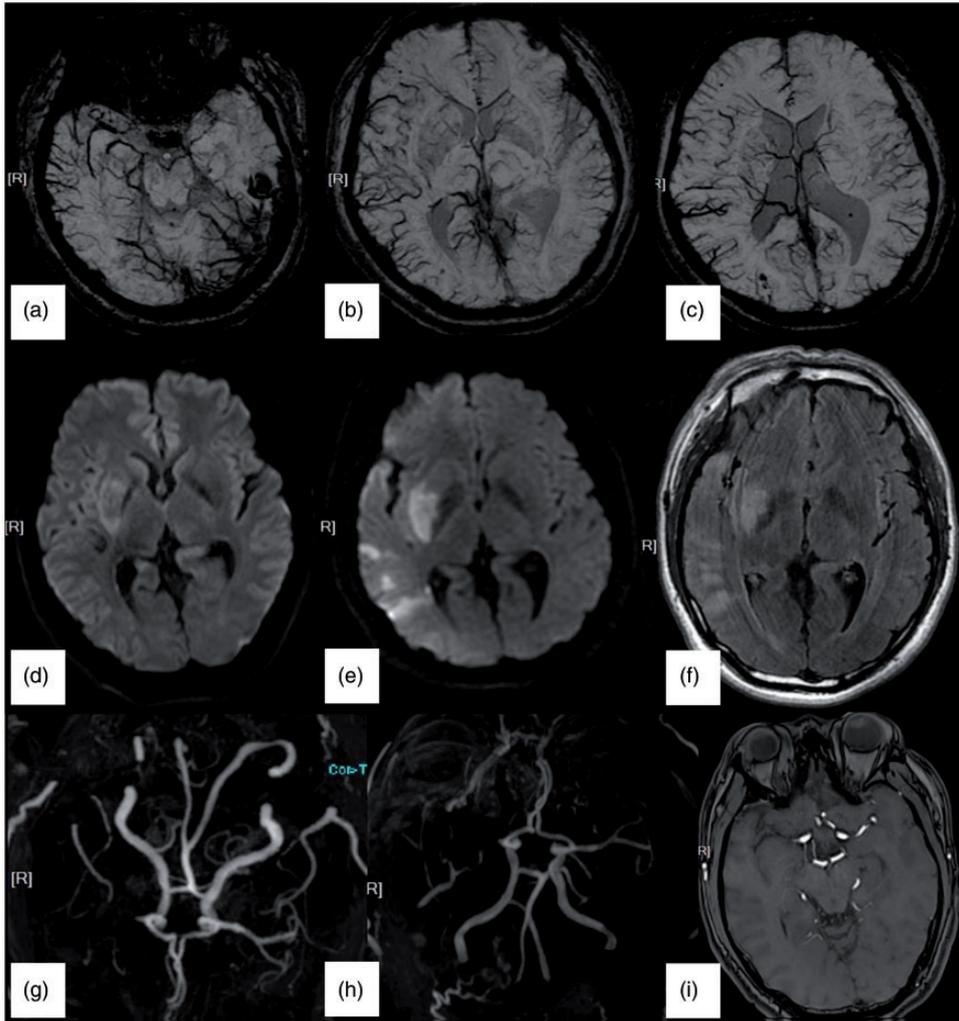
Magnetic resonance images of a 45-year-old man. The baseline and follow-up National Institutes of Health Stroke Scale score was 10 and 6, respectively. (a–c) Baseline susceptibility-weighted imaging minimal intensity projection images show susceptibility vessel sign at the right middle cerebral artery. Prominent vessel sign can be seen at the right middle cerebral artery territory, with an Alberta Stroke Program Early CT score of 4. (d) Baseline diffusion-weighted imaging shows infarction in right basal ganglia, with an Alberta Stroke Program Early CT score of 6. (e) Follow-up magnetic resonance imaging was carried out at 27 hours after baseline imaging. Diffusion-weighted imaging shows enlargement of the infarction, with an Alberta Stroke Program Early CT score of 4. The abnormal area corresponds with the susceptibility-weighted imaging–prominent vessel sign area. (f) A follow-up fluid attenuation inversion recovery image shows a high-signal intensity area at the right temporal lobe, and right insular and right basal ganglia area, which also corresponds with the abnormal susceptibility-weighted imaging–prominent vessel sign area. (g) Baseline minimal intensity projection image of three-dimensional time-of-flight magnetic resonance angiography shows arterial occlusion without distal branches of the right middle cerebral artery. (h–i) Follow-up three-dimensional time-of-flight magnetic resonance angiography shows that the middle cerebral artery is not recanalized after thrombolysis treatment.
